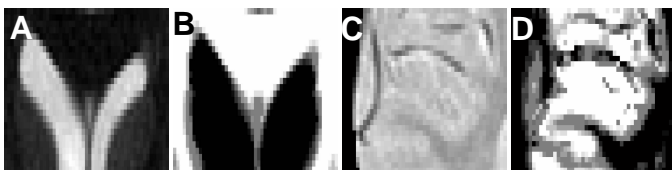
Segmentation quality in close-ups of real brain MRI. (A) Close-up of the top of the ventricles (T₂-weighted slice shown). (B) WM tissue contribution map. (C) Close-up of temporal cortex (PD-weighted slice shown). (D) GM tissue contribution map.
